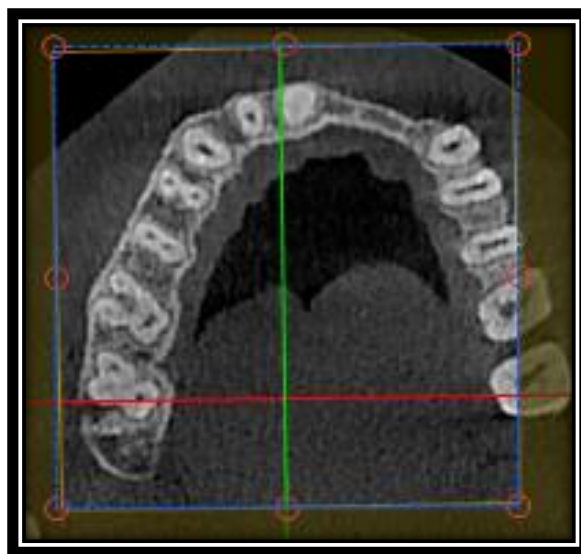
Pre-op CBCT showing calcification of canal
